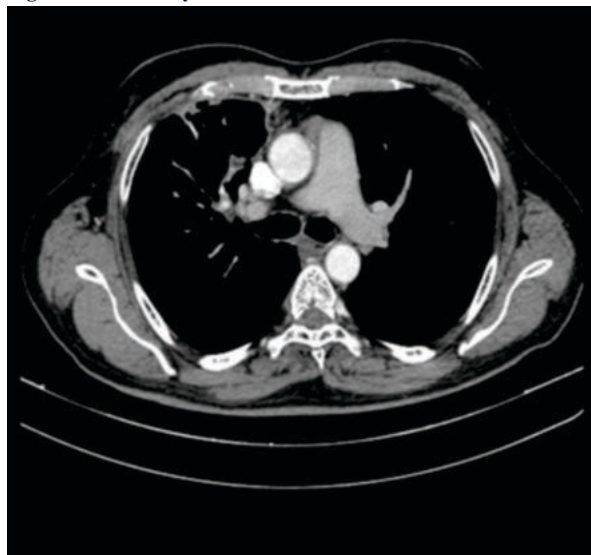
Computed Tomography Thorax at end of treatment
